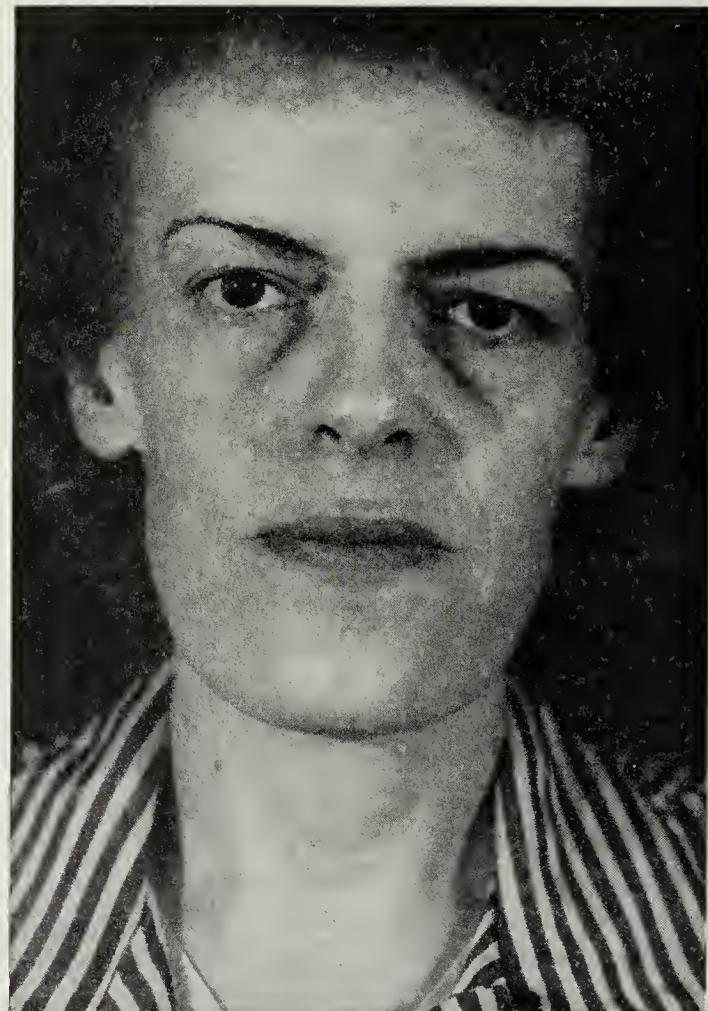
Photograph of a 44-year-old woman with acromegaly, arrested. Onset of the disease occurred 20 years before, at which time a moderately enlarged sella turcica was demonstrated by x-ray. Following x-ray therapy of the pituitary she has shown no further progression of the disease.
